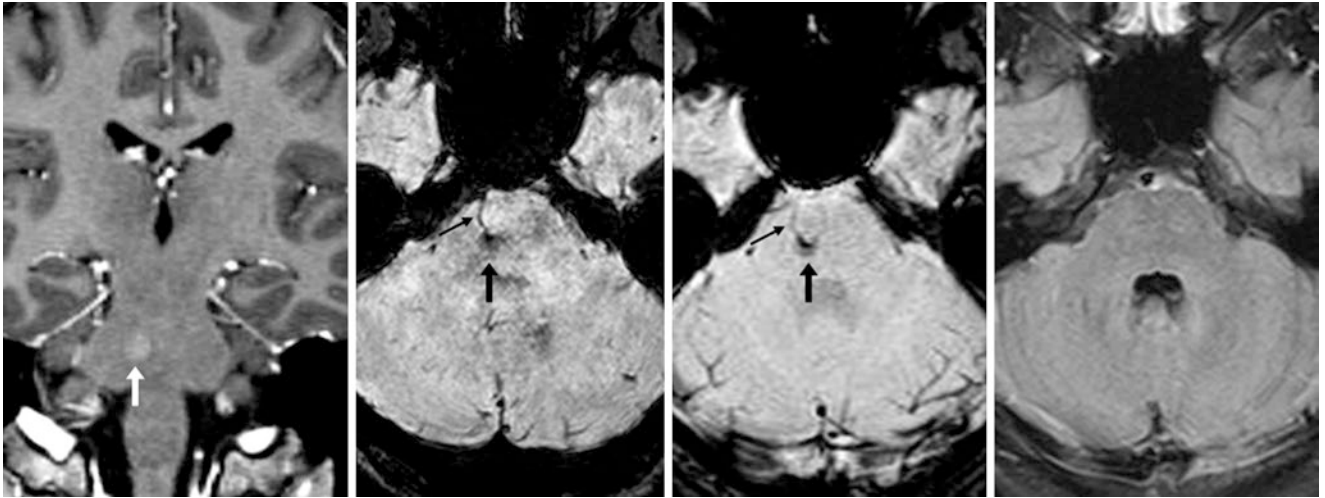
A 17 year old with nausea in whom a 1.5T MRI demonstrated faint enhancement of a pontine BCT (*arrows*) on postcontrast coronal GE T1WI (*left*) having faint dark signal on 2-mm-thick SWI
